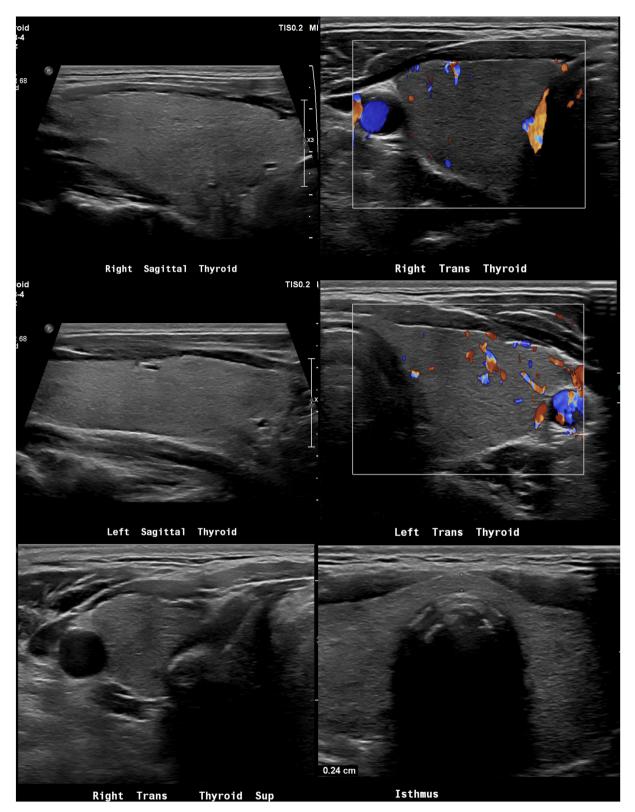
Ultrasound of the thyroid showing diffusely enlarged thyroid gland, *right* lobe 6.1 × 2.8 × 2 cm, *left* lobe 6.1 × 2.8 × 2 cm, isthmus thickness 0.24 cm, the approximate total volume of 13.5 ml (normal:7 - 10 mL), thyroid appears homogeneous without evidence of discrete nodules or increased vascularity.
